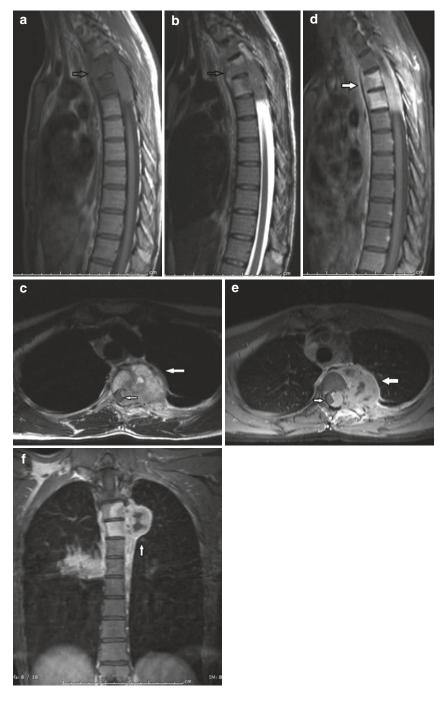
A 24-year-old woman. (a) Sagittal T1-weighted MRI shows heterogeneously hypointense signal (*arrow*) in T3–T4 vertebral bodies with epidural mass. (b) T3 and T4 vertebral bodies are heterogeneously hyperintense (*arrow*) on sagittal turbo spin-echo T2-weighted image. (c) Axial T2 -weighted MRI shows heterogeneous hyperintense signal in T1–T2 vertebral bodies and left pedicle. In addition, there is infiltration of left paraspinal and spinal canal region with abscess formation and displacement of the spinal cord.
